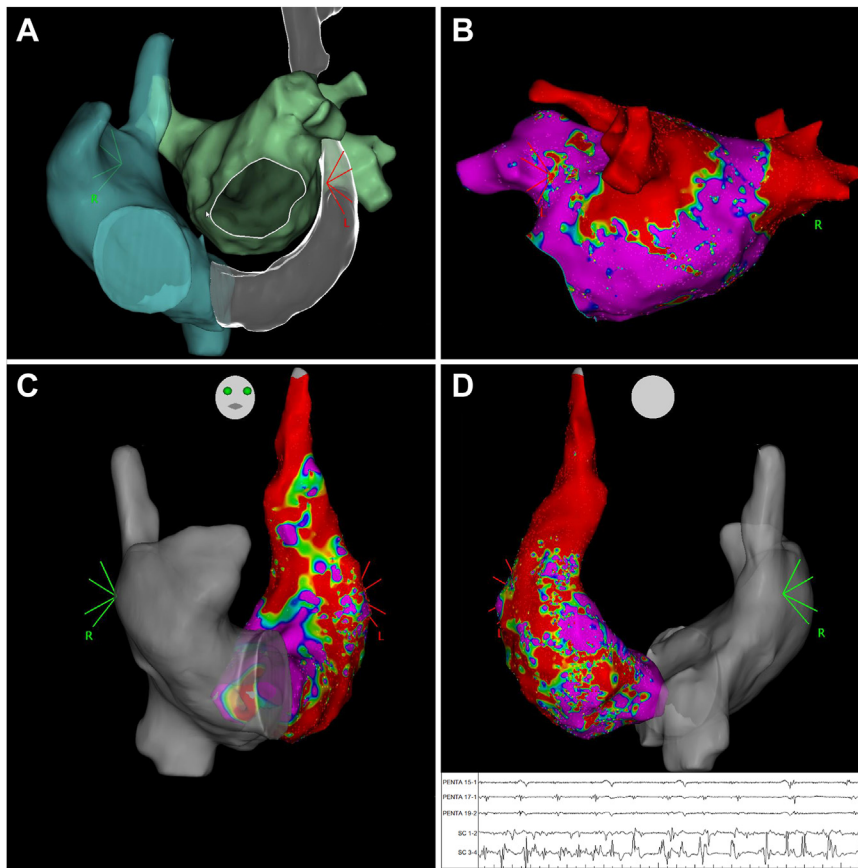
A: Three-dimensional reconstruction of computed tomography scan imaging showing the left atrium (blue), right atrium (green), and left superior vena cava (LSVC) (white). B: Baseline voltage map of the left atrium showing previous effective pulmonary vein isolation and normal mitral isthmus signals. C, D: Baseline voltage map of the LSV showing widespread heterogeneous signals throughout the entire length of the vein and endocardial recordings showing electric activity with higher frequency and amplitude in the coronary sinus (SC) than on the endocardial surface of the left atrium (PENTA).
